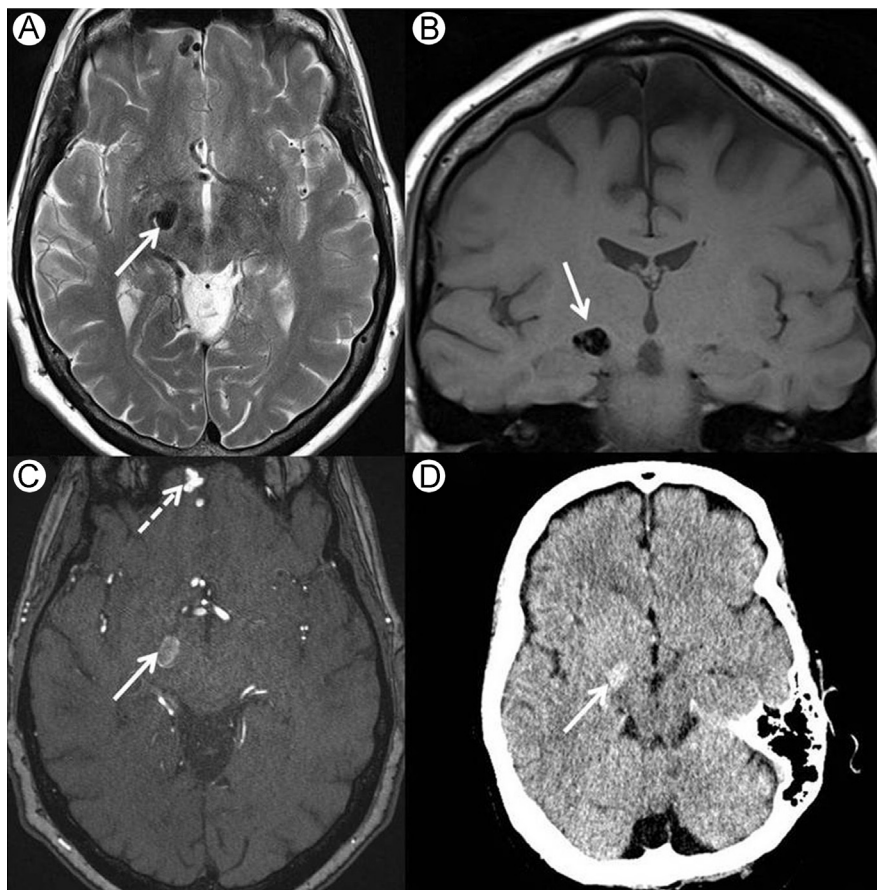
A patient presenting with a left superior quadrantanopia: (A) axial T2-weighted, (B) coronal T1-weighted, (C) axial time-of-flight MR angiogram, and (D) unenhanced CT. There is a pial AV fistula supplied by the anterior ethmoid arteries (not shown). Dilated draining veins are seen in the anterior hemispheric fissure (dashed arrow, C), a dilated venous pouch (arrows, A-D) is compressing the right lateral geniculate nucleus. AV, arteriovenous; CT, computed tomography.
